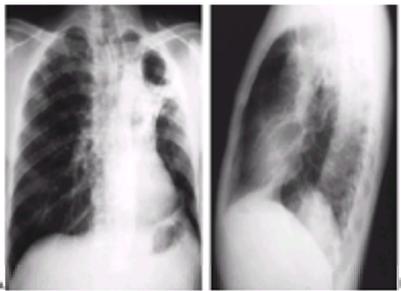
Posteroanterior (A) and lateral (B) chest x-ray films of case 1 after the completion of treatment for tuberculosis. Note the clearing of disease in the right lung with residual cavitation and scarring in the left lung with volume loss.
